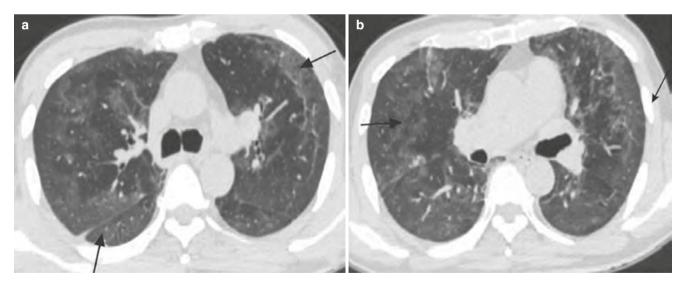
Eosinophilia syndrome. (a, b) CT lung window showed multiple patchy ground-glass opacities in both lungs, with peripheral distribution (arrow)
